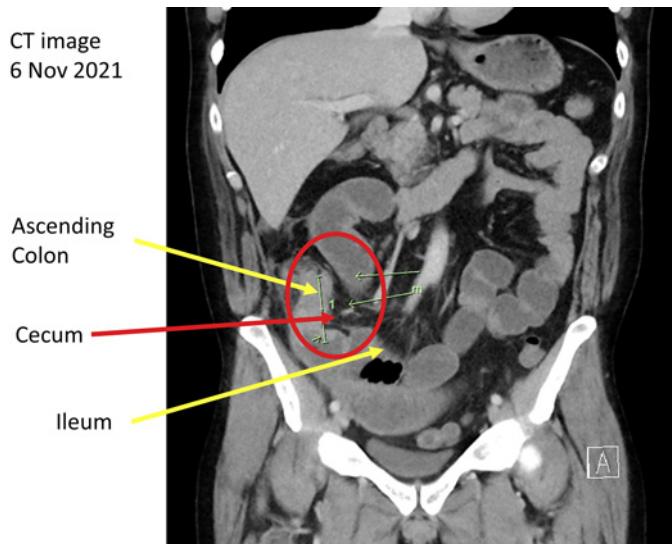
Location of suspected primary tumour by computed tomography imaging. The patient's colorectal primary tumour, arising in the cecum (red arrow), a pouch connected to the junction of the small and large intestines, appeared as small bowel obstruction (black area in red circle) measuring 5.17 cm in length (green arrows). Pathology of the resected tissue confirmed a G1 low-grade adenocarcinoma with adhesion to the abdominal wall and soft tissue and involvement of two out of 20 lymph nodes. The T4bN1 tumour was removed by right hemicolectomy.
